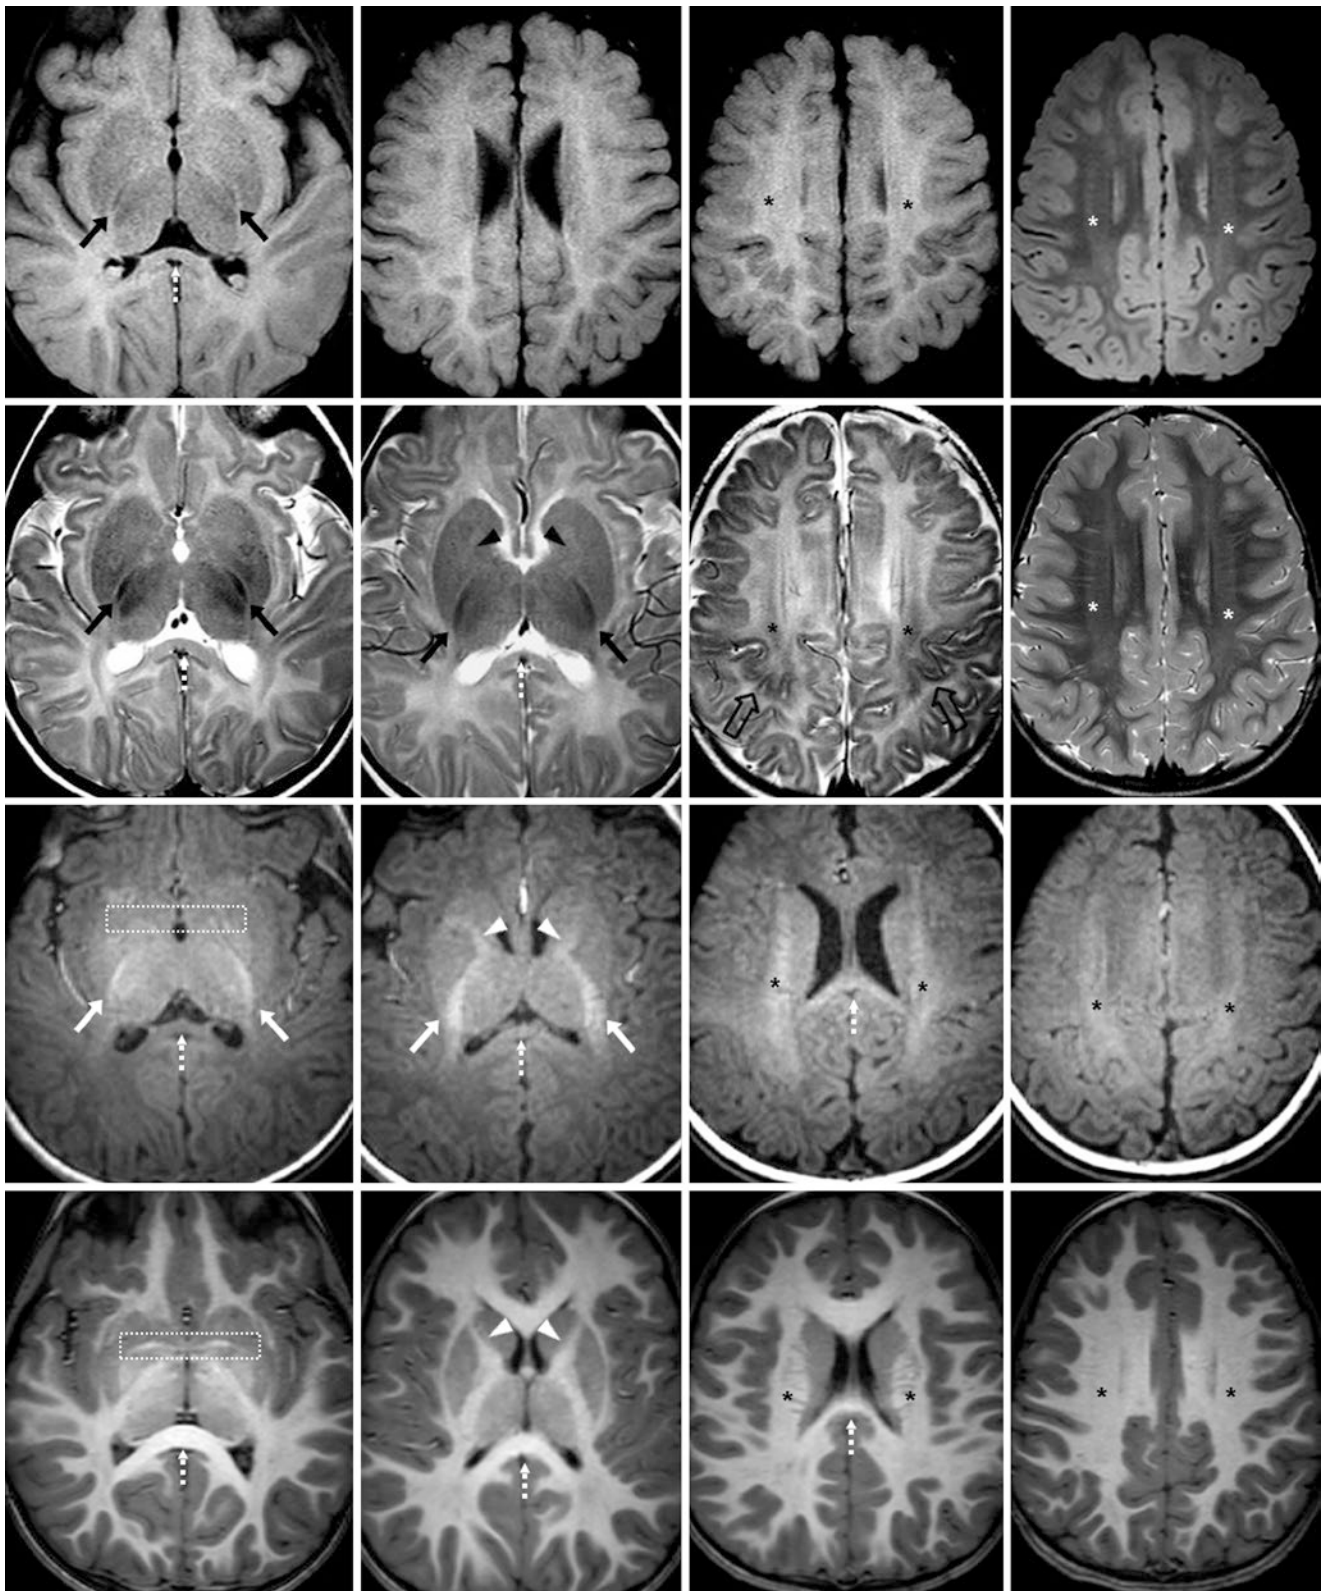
A 13-week-old with possible abusive trauma, who had a negative 3T MRI, and developed normally. *Top row:* FLAIR images show the hyperintense PVWM and SCWM, which regresses by 1 year of age. Note the dark PLIC (*arrows*). At 3 years of age (*right*), note that the gray matter-white matter pattern has reversed to the adult appearance. *Second row:* SE T2WIs show PLIC myelination. The centrum semiovale (*asterisks*) is darkening (*asterisks*). The frontoparietal gyri have darkened nearly to the PRC (*open arrows*). At 3 years of age, there is white
